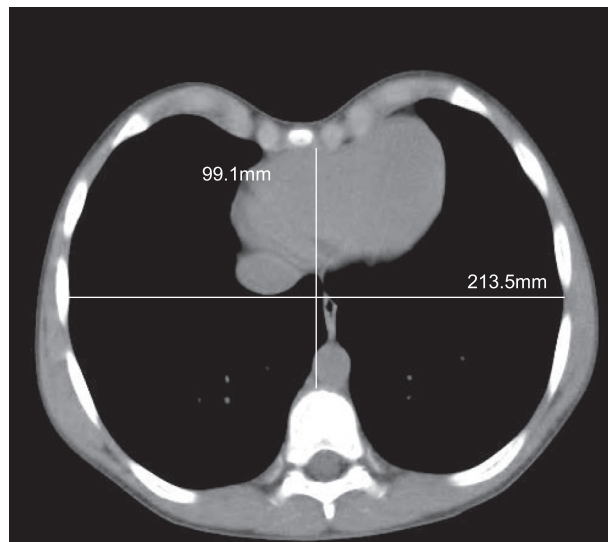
CT image of the pectus patient with the lowest HI.
